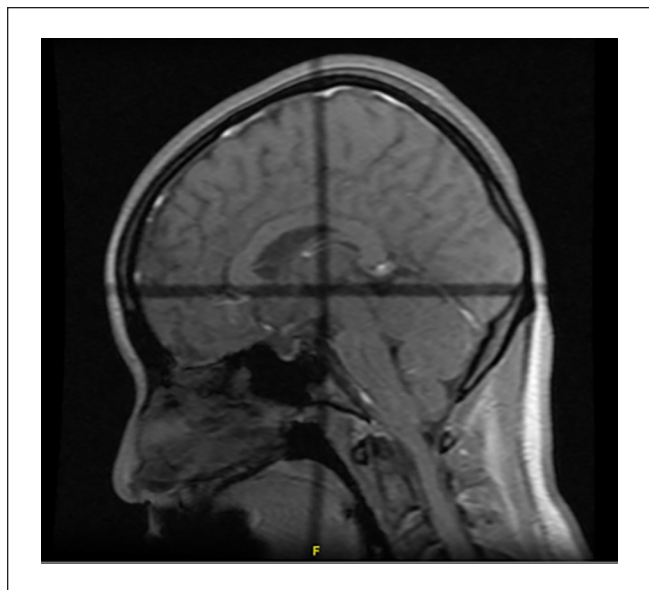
Leptomeningeal enhancement on brain MRI, a finding which may be seen in cryptococcal meningitis.
